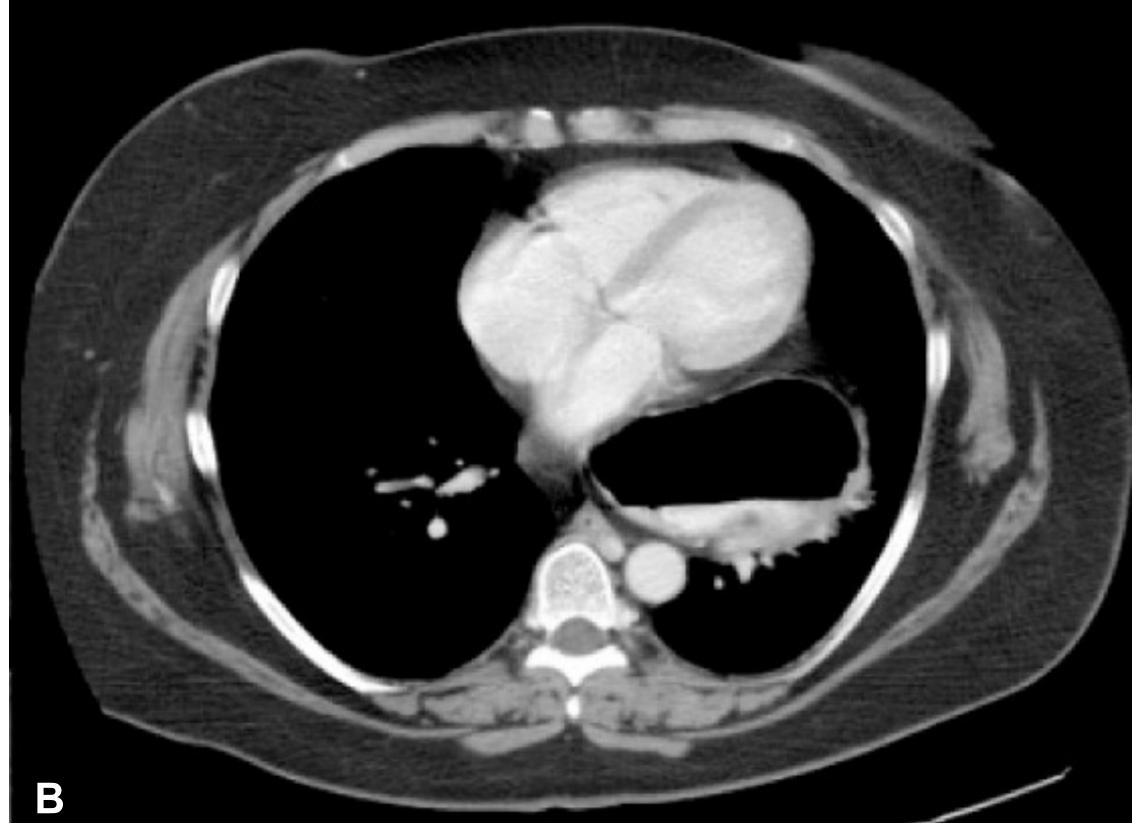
CT A/P demonstrating a large hiatal hernia.
